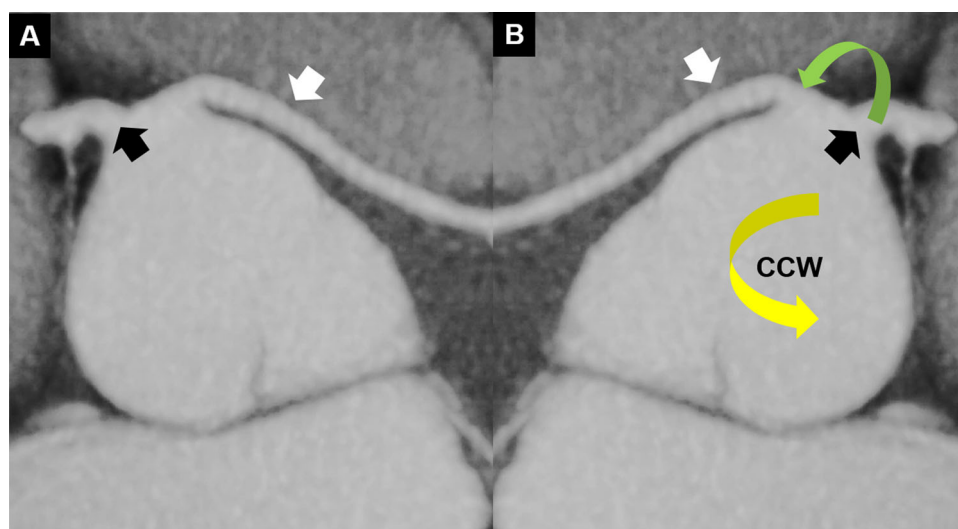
Catheter maneuver to engage left main or left anterior descending artery with retropulmonic course. (A) Computed tomographic image displaying an anomalous left anterior descending artery (white arrow) arising from the right sinus near the right ostium (black arrow) and exhibiting a retropulmonic course. (B) Inverted tomographic image demonstrating the maneuver to move the catheter (green arrow) from the right ostium to the left anterior descending artery using a counterclockwise (CCW) rotation (yellow arrow). [Color figure can be viewed at wileyonlinelibrary.com]
